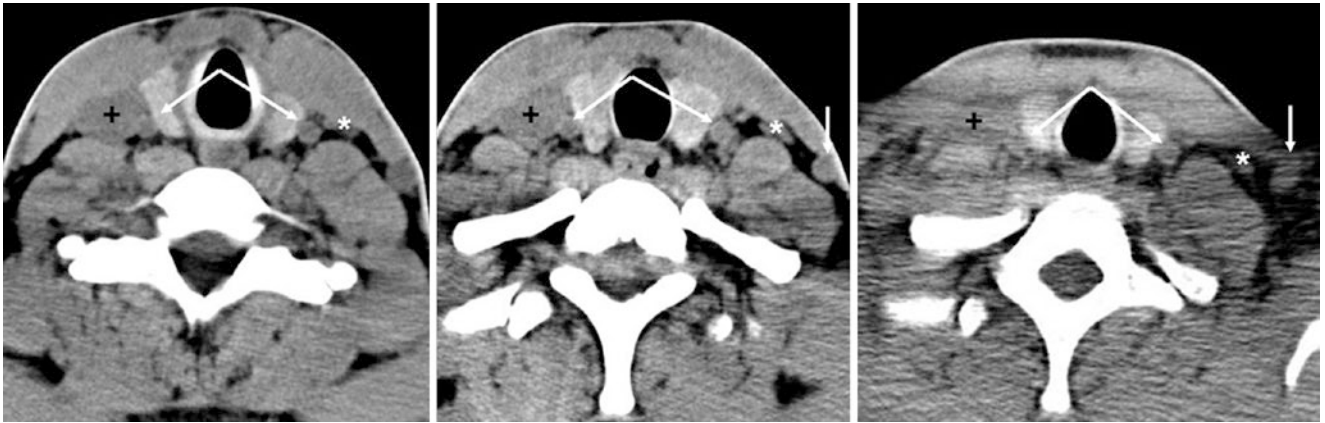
In this 21-year-old who fell, axial nonenhanced CT images (left two images) show that the right IJV (*plus sign*) is dominant at 23 mm, whereas the left IJV (*asterisk*) is moderately hypoplastic at 7 to 8 mm maximum axial diameter, unchanged from 4 months earlier
